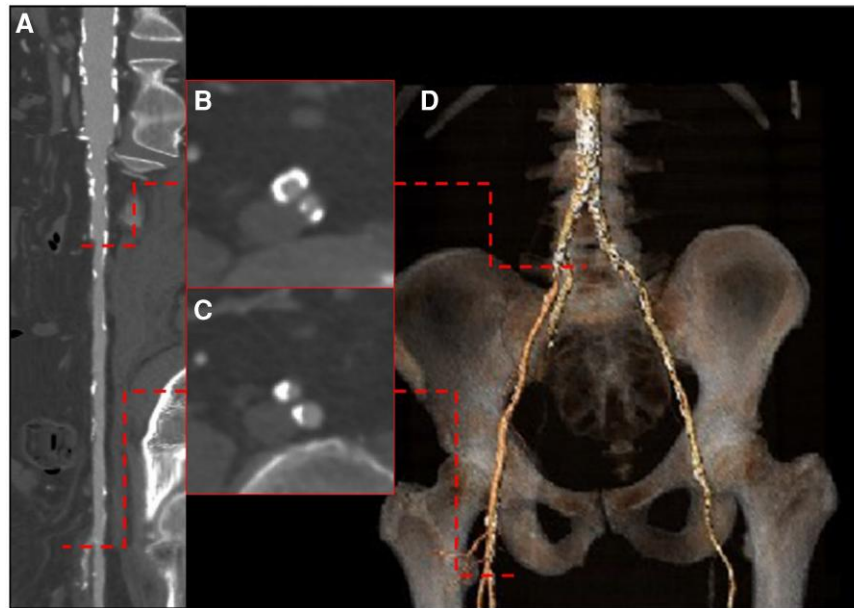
Computed tomography. (A) Bidimensional long axis reconstruction of right iliac-femoral axis. (B, C) Cross-sectional visualization of the minimum lumen area. (D) 3D iliac-femoral axis reconstruction.
